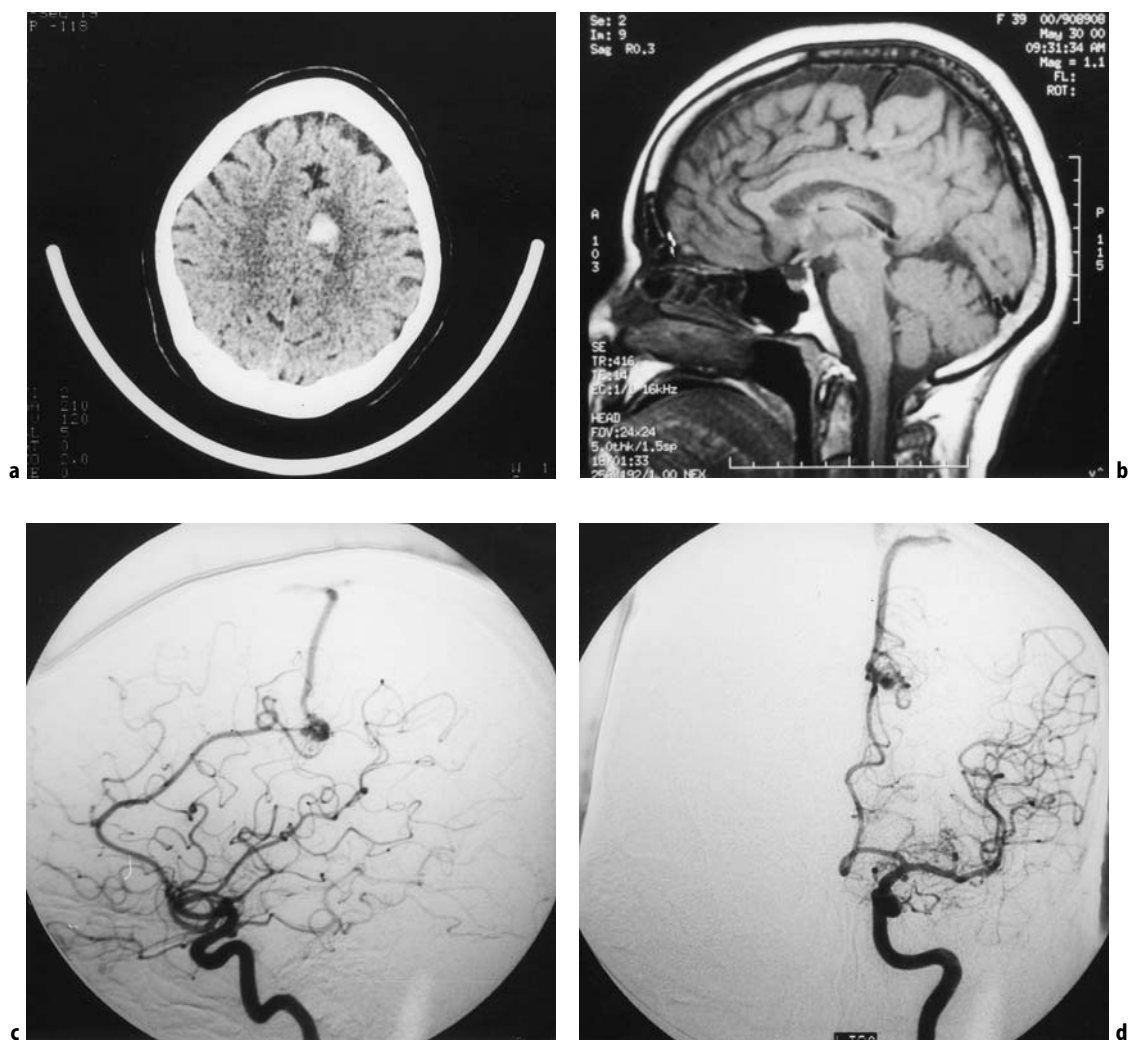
Case 2: A 39-year-old female presented with sudden right-sided hemiparesis and headache. a An axial non-contrast CT scan revealed an acute intracerebral hemorrhage in the left medial centrum semiovale. A cerebral angiogram revealed a left-sided 1-cm paracentral lobule AVM. The patient had significant recovery of her hemiparesis from intensive rehabilitation. A MRI and repeat cerebral angiogram was performed 4 weeks after her ictus for treatment planning. b A mid-sagittal T1-weighted non-contrast MRI displayed evidence of the AVM. Although small, a collection of vessels was noted at the distal callosomarginal artery territory in the cingulate sulcus anterior–inferior to the paracentral lobule. A prominent linear draining vein was noted in the paracentral sulcus subsequently entering the superior sagittal sinus. The paracentral lobule was markedly atrophic, presumably from her previous hemorrhage. c A lateral left internal carotid mid-arterial phase cerebral angiogram revealed a 1-cm AVM, being fed by the callosomarginal artery. Perpendicular to the feeding artery, early opacification of the malformation’s draining vein was noted. d An AP left internal carotid mid-arterial phase cerebral angiogram further defined the midline AVM. There were no aneurysms or deep venous drainage present. This AVM was classified as a Spetzler–Martin Grade 2 (1 for size, 1 for eloquence (motor cortex) and 0 for deep venous drainage). This patient opted for surgical removal. Frameless stereotaxis was used during the operative procedure to define the nidal margins.
